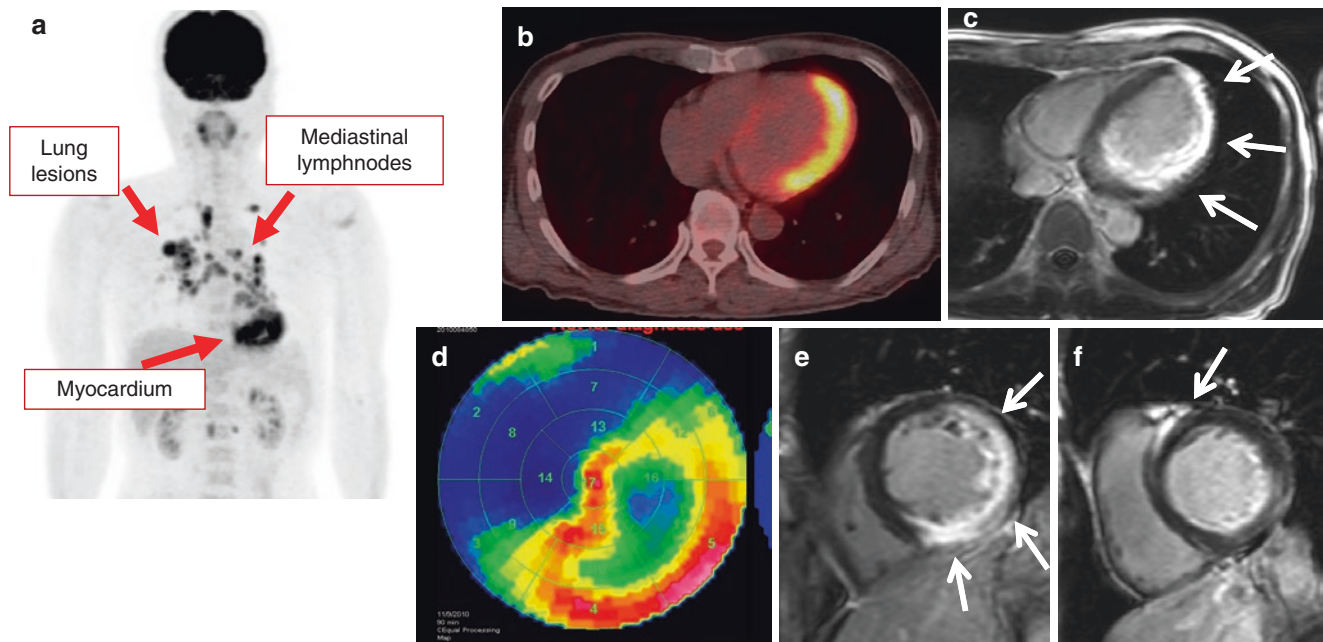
Maximum intensity projection (MIP) view of the FDG PET (a). There are abnormal uptake in right upper lung lesions, mediastinal lymph nodes, and left myocardium. PET/CT shows significant FDG accumulation in the apico-lateral myocardial wall on trans-axial view (b). On the same view, MRI shows LGE in the similar regions including
